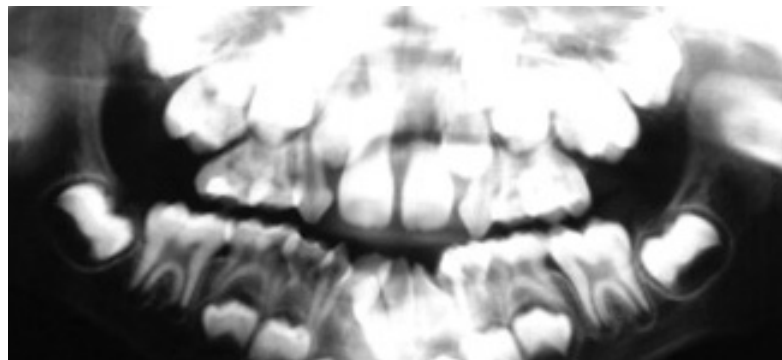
Panoramic radiography in a male case of Crouzon syndrome.
